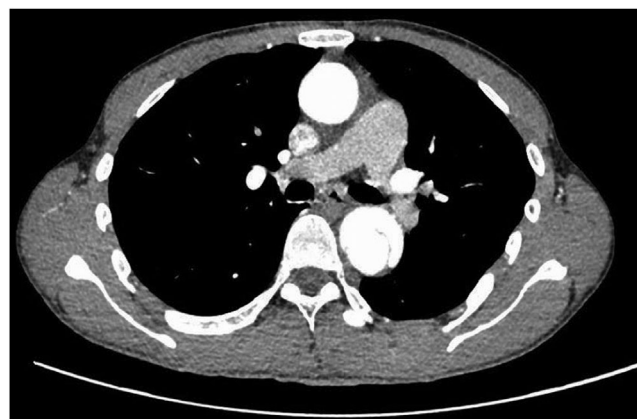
Computed tomography of the aorta.
